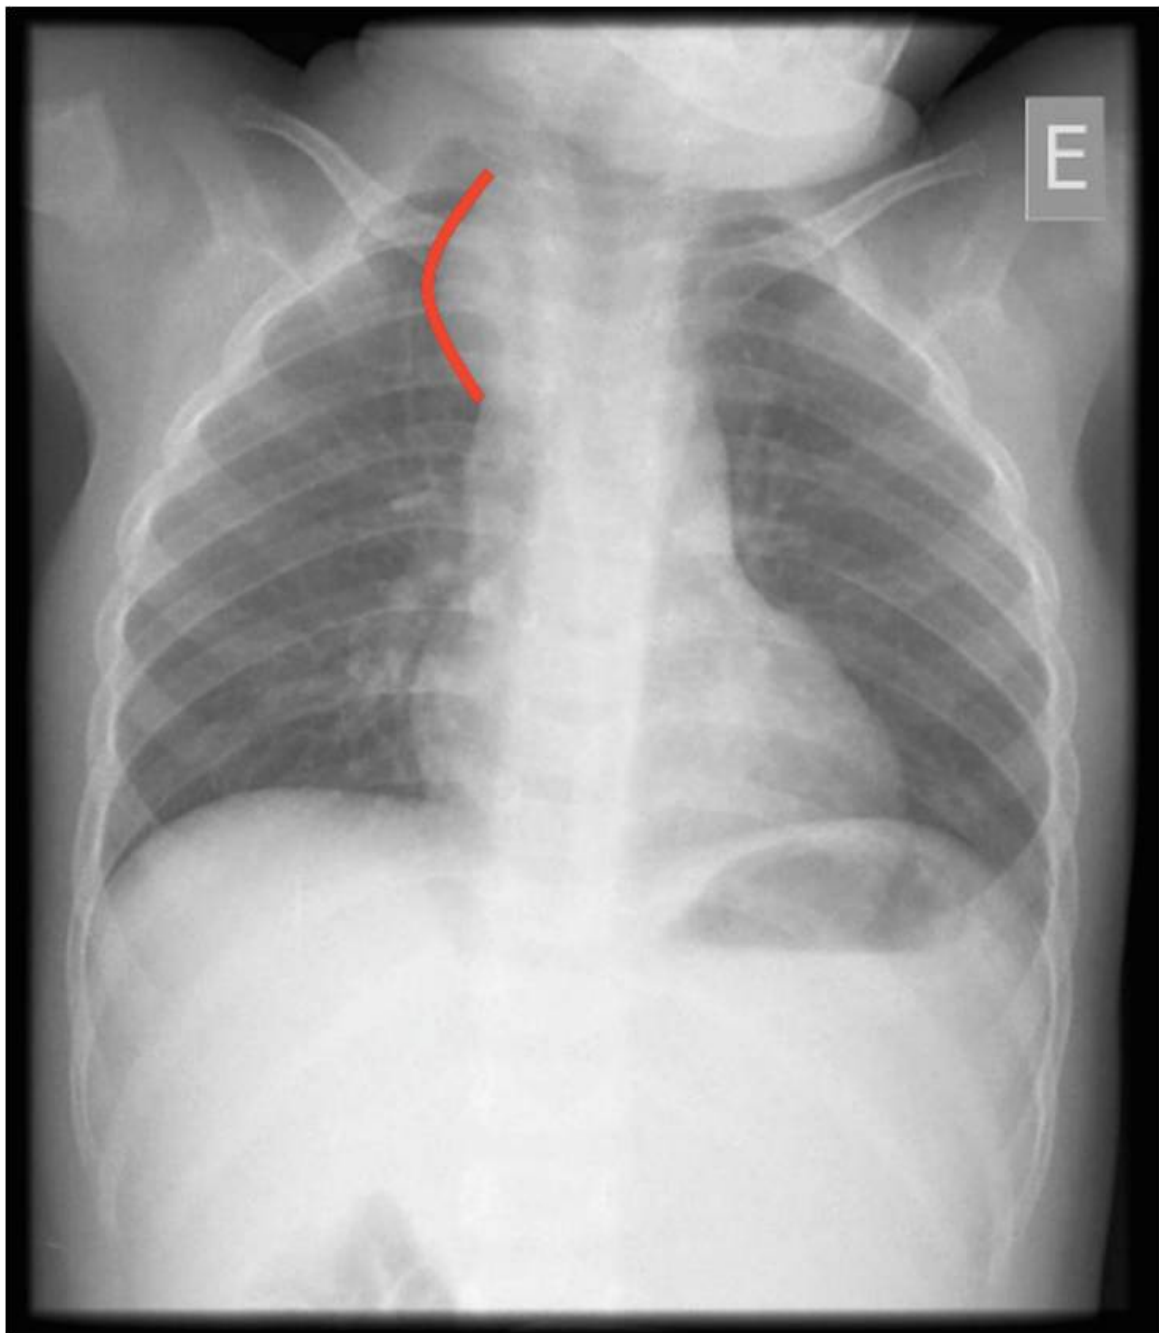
Chest X-ray with a hypotransparent image in the right upper lobe.
